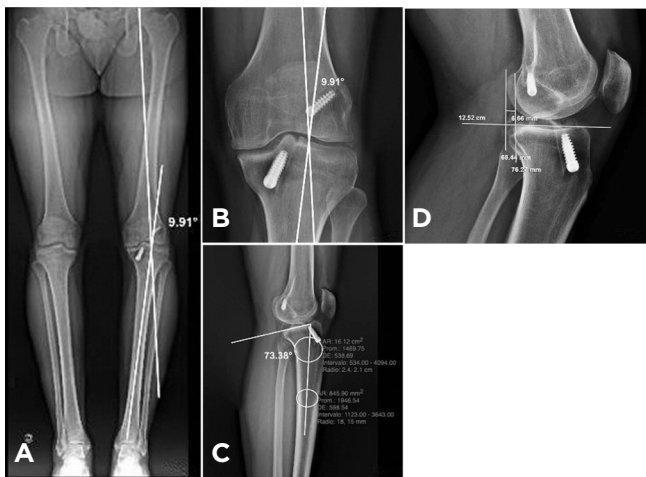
A) Preoperative weight bearing full-length radiograph demonstrates varus deformity of nearly 10° with hardware from the primary ACLR; B) Anteroposterior radiograph of the knee shows varus alignment and mild medial joint space narrowing with intact hardware from prior bone tendon bone autograft ACL reconstruction; C) Preoperative lateral weight bearing radiograph of the left knee displaying a PTS of nearly 17°; D) Preoperative anterior tibial subluxation (ATS) measured 6.66 millimeters on lateral radiographs.
